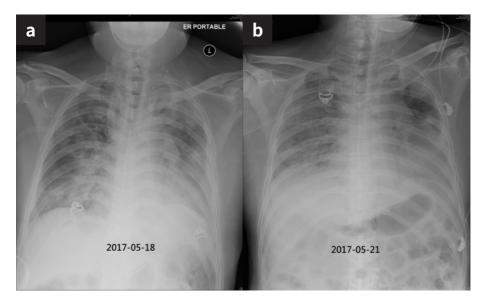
Chest radiography (05-18-2017 and 05-21-2017) showing bilateral diffusive consolidation.
